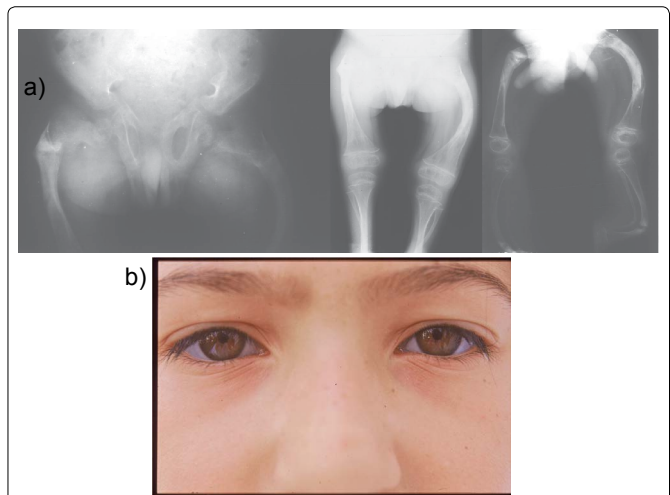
a) A 5-year-old boy, with kyphoscoliosis, abnormal teeth and short stature, suffering from type III osteogenesis imperfecta. Considerable deformity of the femora and tibiae, fractures developing callus formation and pseudarthrosis at sites of healing fractures were evident on radiographs; b) Clinical appearance of a 9-year-old girl, with blue sclera and mildly depressed nasal bridge, suffering from type I-A (normal teeth) osteogenesis imperfecta.
